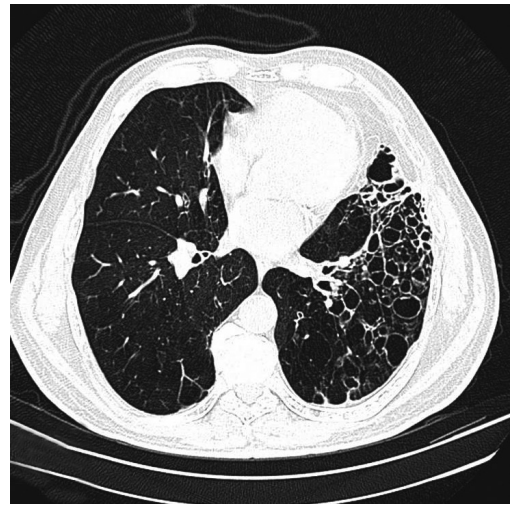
Follow-up chest CT scan (1 month later) showing cystic bronchiectasis, fibrotic changes and regions of scarring on the left lower lobe.
